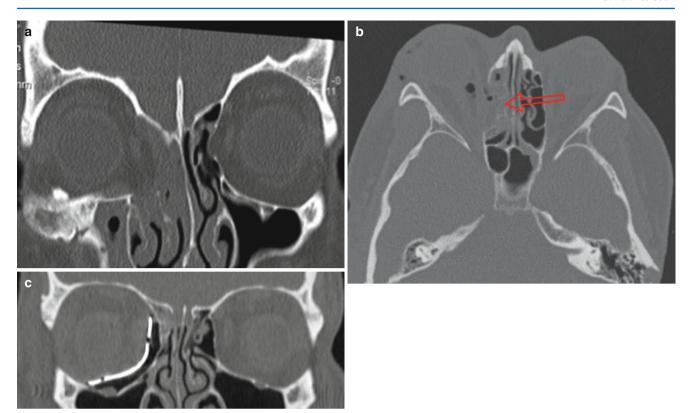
Pre- and postoperative CT images (a–c)
